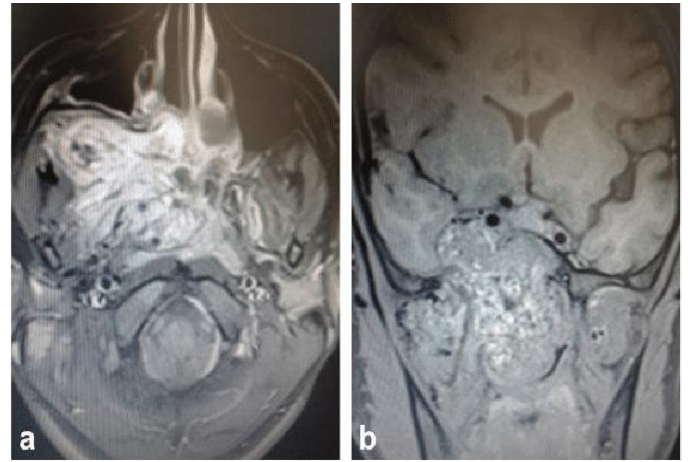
MRI Axial and Coronal view showing typical salt and pepper appearance of JNA.
